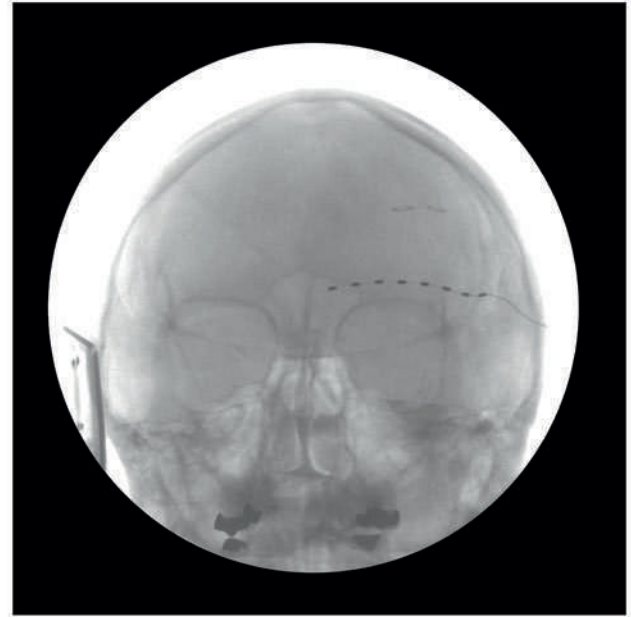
Anterior-posterior radiograph demonstrating trial placement of an 8-contact lead for supraorbital stimulation.
